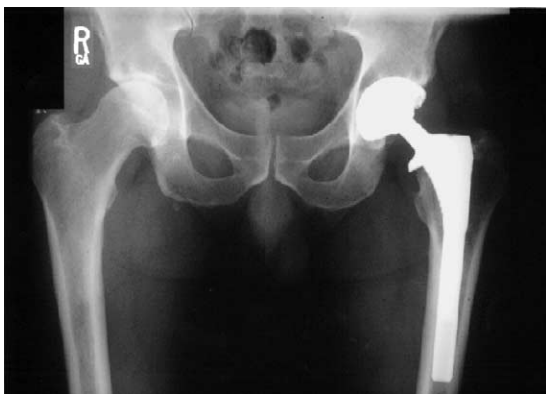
Case 2. Two years–postoperative anteroposterior pelvis radiograph of left hip arthroplasty with a non-cemented Anatomic Porous Replacement stem and non-cemented Converge acetabular cup and a 28-mm Metasul head and liner. This prerevision anteroposterior pelvis x-ray demonstrates well-fixed femoral and acetabular components with no radiolucencies or osteolysis.
